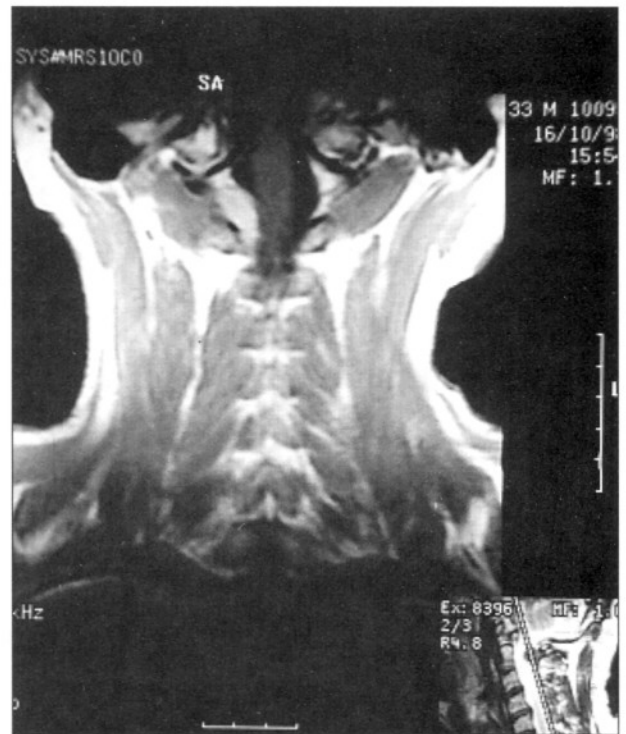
Contrast-enhanced coronal T1-weighted MRI shows enhancement of the same lesion at C2 level.
